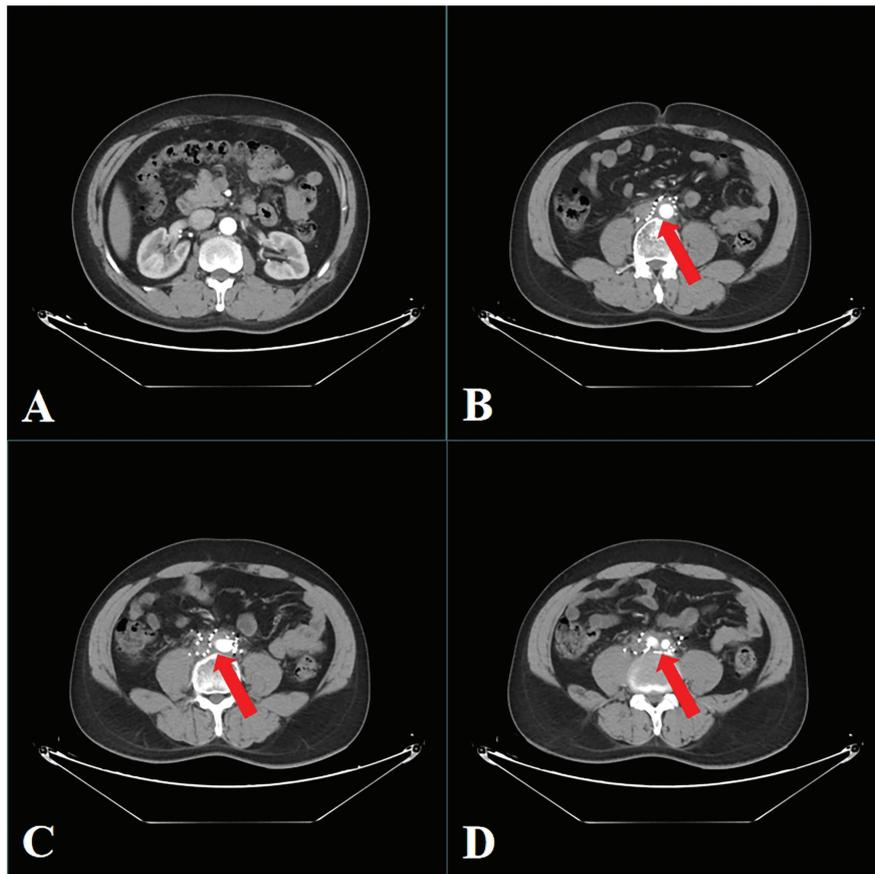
Computed tomography reexamination 2 months after surgery showing that (A) the right kidney had returned to a normal shape and (B) the metastases around the abdominal aorta had completely subsided. (C) After the metastasis around the abdominal aorta had subsided, iodine-125 seeds were arranged in a contractile pattern. (D) The metastases around the bilateral iliac vessels were also completely subsided.
